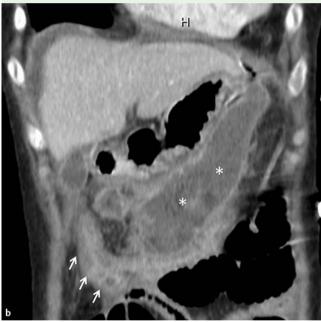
Computed tomography (CT) scan of the upper abdomen in a 28-year-old woman with chronic glomerulonephritis, pneumonia, and acute necrotizing pancreatitis showing: a a walled-off area of necrosis in the pancreas (arrows) containing an air bubble (\*) in axial view; b a walled-off area of necrosis in the transverse mesocolon (\*) with pressure effect on the transverse colon (arrows) in coronal
